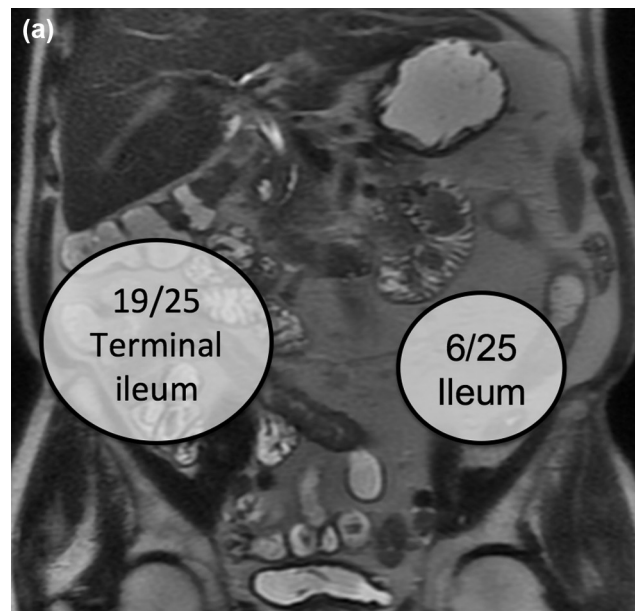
(a) Distribution of the segmental inflammation in the study population. (b) Motasso-Software interface. The figure demonstrates the MRI-sequence showing the motility in the middle of the interface with the resulting small bowel motility analysis used to plot the motility curve underneath.
